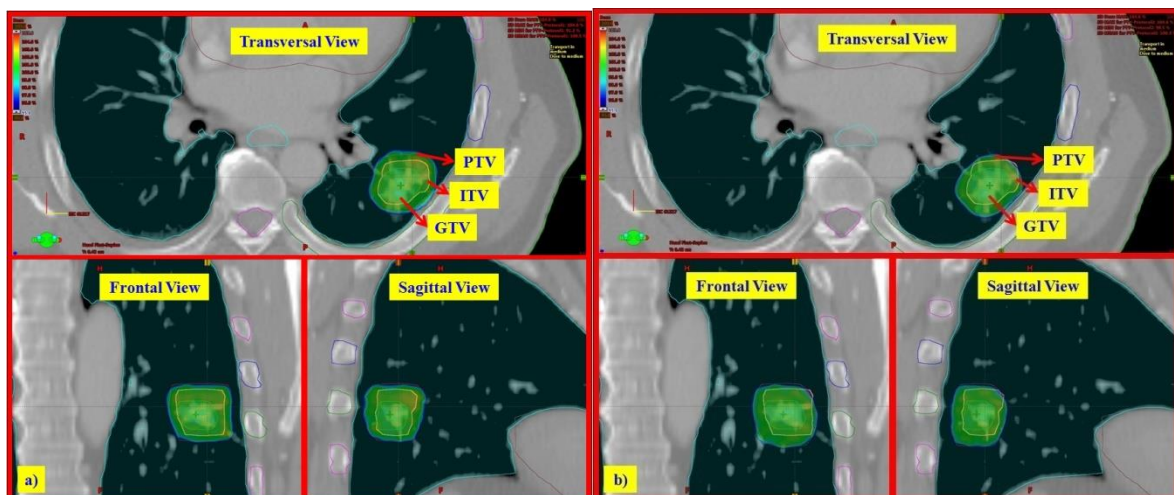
Variation of dose distribution in ITV due to strategies for PTV delineation (a) proposed strategy to delineate from ITV using multiple-phase 3D-CT (b) standard strategy to delineate from GTV using single
